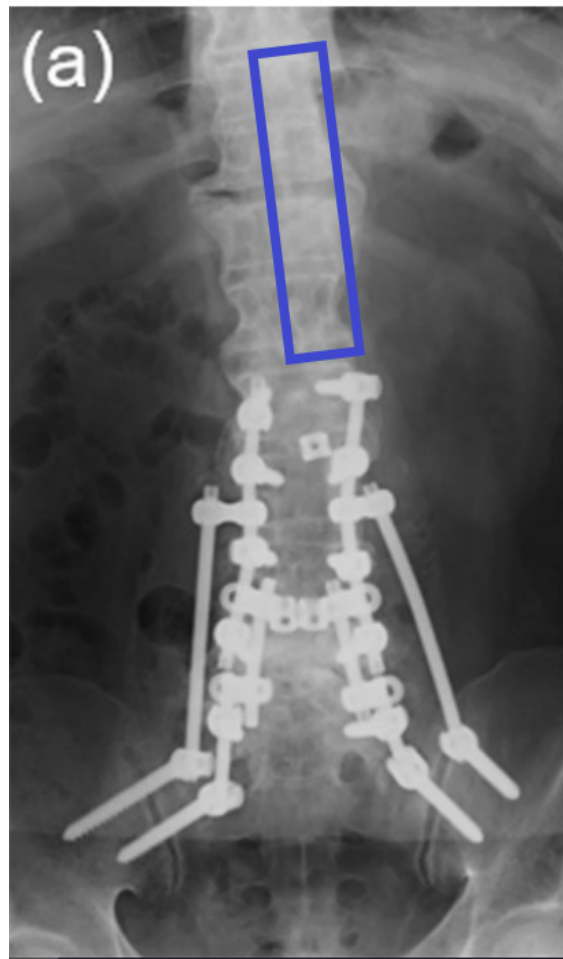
Anterior-posterior x-ray image from 48-year-old woman with DISH showing, with the blue rectangle, the ossifications of the AAL [78].
